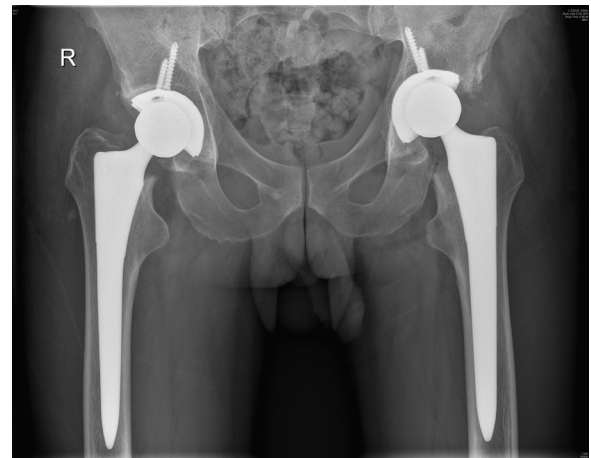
Postoperative X-ray imaging.
